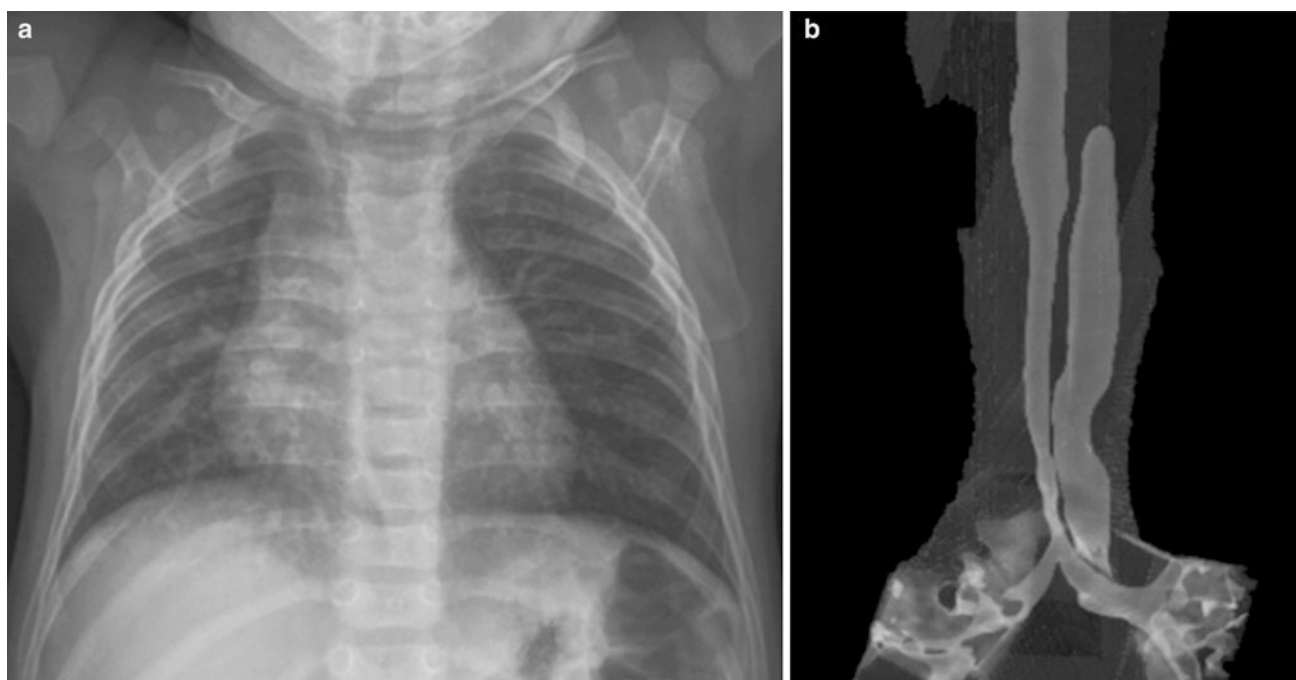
Frontal chest radiograph (a) and CT coronal volume rendering image of the trachea (b) in a child with type II pulmonary sling. Note the low T-shaped carina and the long segment narrowing of the intrathoracic trachea
